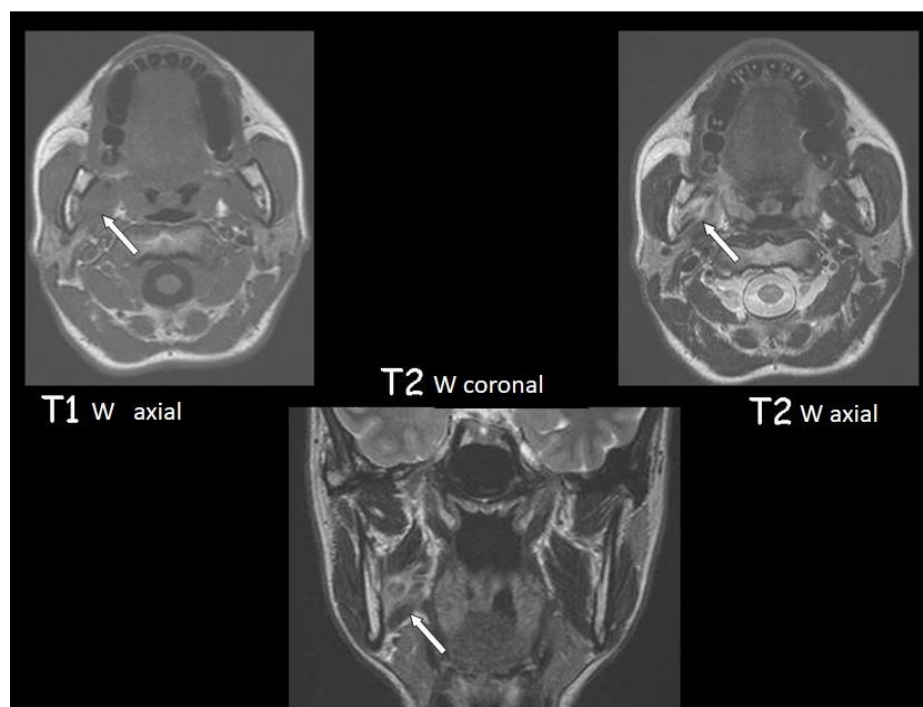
MRI of the maxillofacial structures with axial T1- and T2-weighted and coronal T2-weighted scans. The white arrow indicates the lesion inside the right internal pterygoid muscle which is isointense in T1 and hyperintense in T2.
